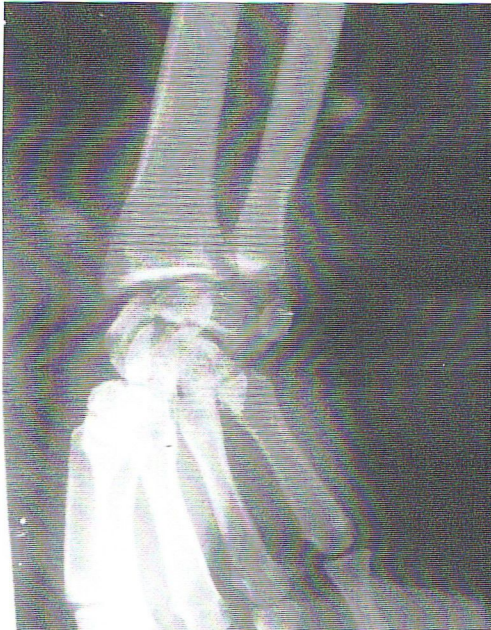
Hand-wrist X-rays: young girl
